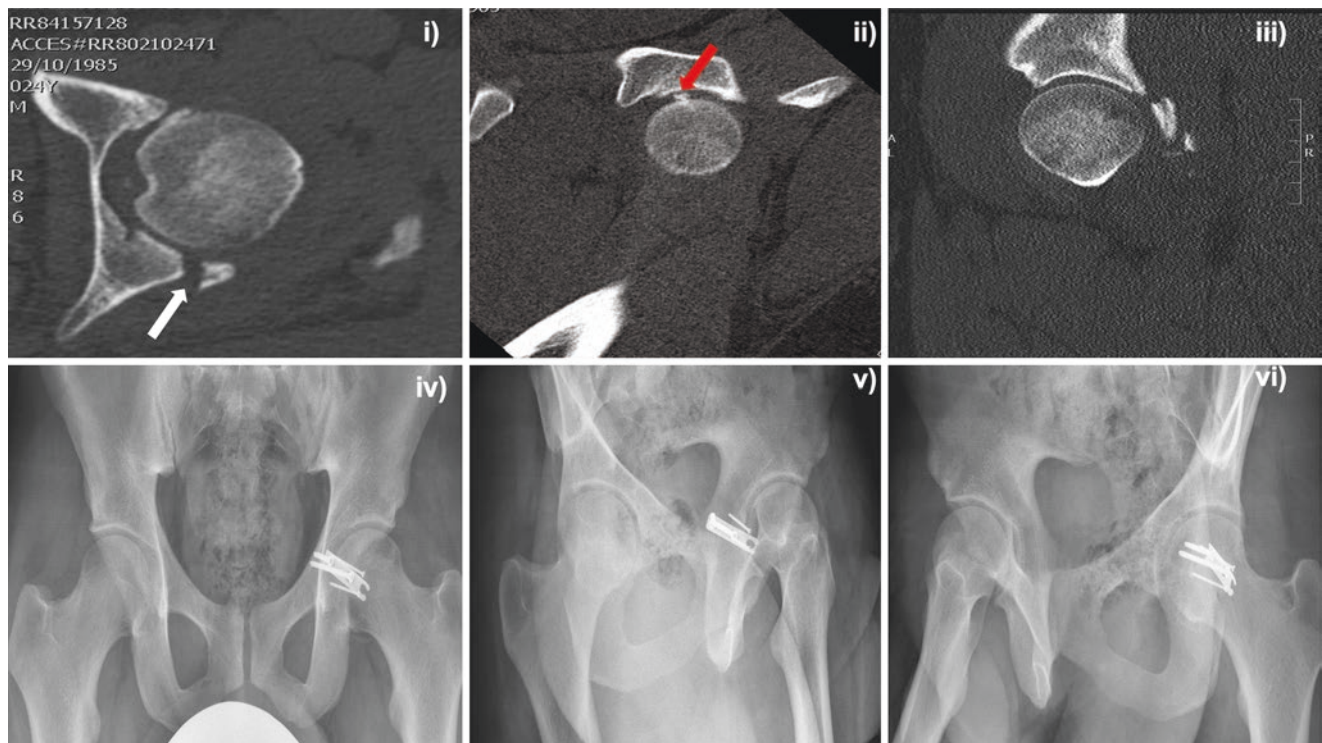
(i–iii) CT pelvic cuts in a 28 year old professional rugby player who sustained a fracture dislocation of his left hip during a match. The hip was reduced at the accident and Emergency Department. In slice (ii) an incarcerated bone fragment is shown. (iv) Using a Kocher
